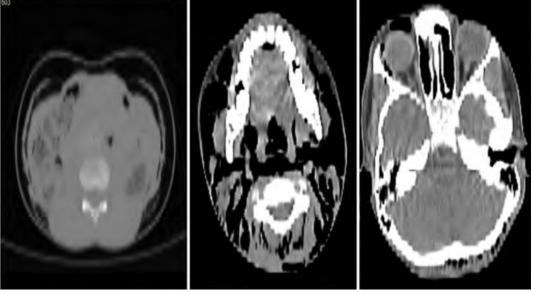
Axial sections of abdomen, chest, neck and brain CT-scan with contrast shows pneumomediastinum and subcutaneous emphysema extension from lower abdomen to periorbital region
